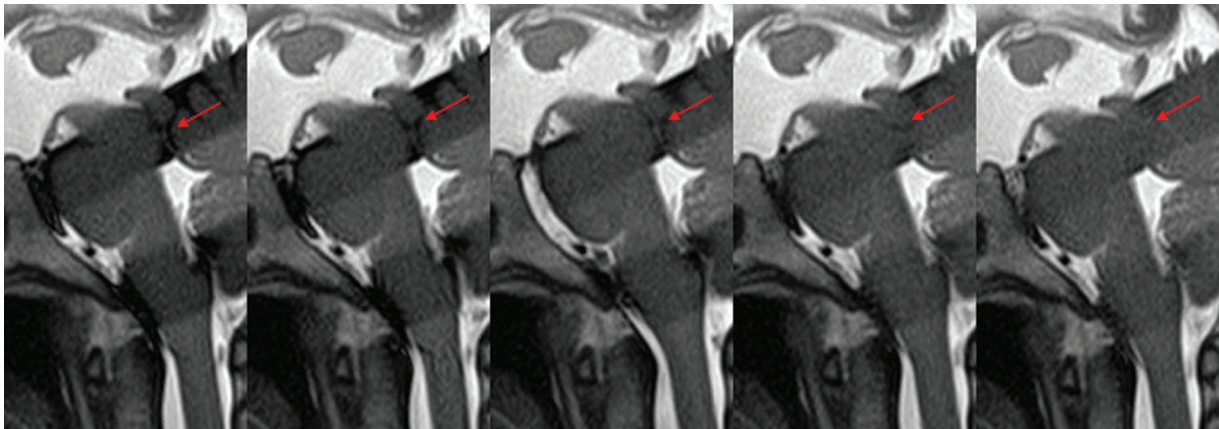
Preoperative magnetic resonance image with time-spatial labeling inversion pulse showing no cerebrospinal fluid flow from the third ventricle to the aqueduct (*red arrow*).
